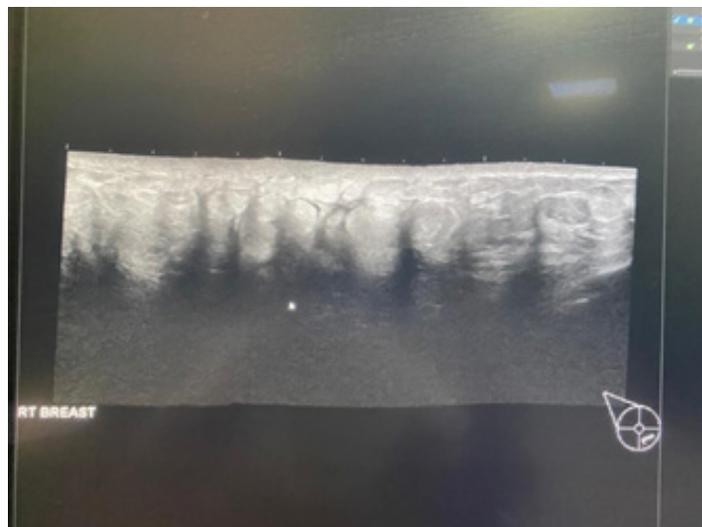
Ultrasound panoramic view showed diffusely altered echogenicity of the right lower inner quadrant with hyperechoic and intervening hypoechoic areas, posterior acoustic shadowing. No obvious collection noted. No internal vascularity
